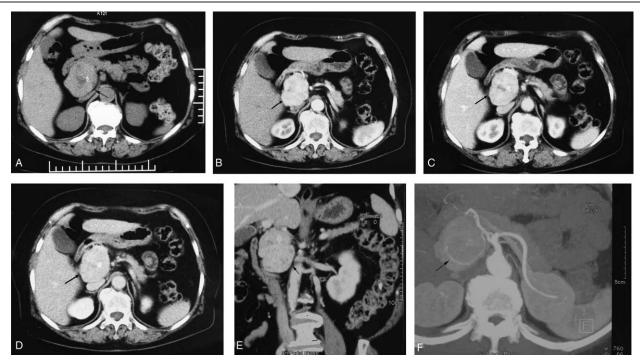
Abdominal computed tomography (CT) scan findings (black arrow). (A) Unenhanced CT showed inhomogeneous, ovoid mass (60 mm × 50 mm), with a well-defined margin and small sheetlike calcification and cystic degeneration. (B–D) The lesion demonstrates heterogeneous contrast enhancement on arterial phase (after 35–40 seconds), portal phase (after 40–60 seconds), and delay phase. (E) Coronal axes showed the location of the mass. (F) 3D reconstruction of vessels showed rich blood supply from the celiac trunk.
